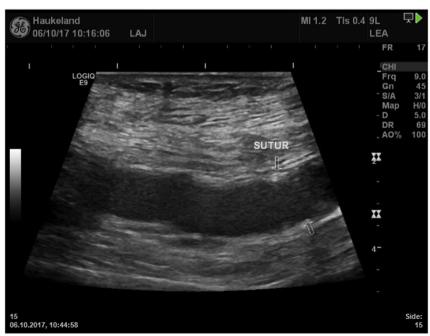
Duplex ultrasound scan of a popliteal spiral vein graft at 12 months post-operatively. The arrows point to the distal anastomosis.
